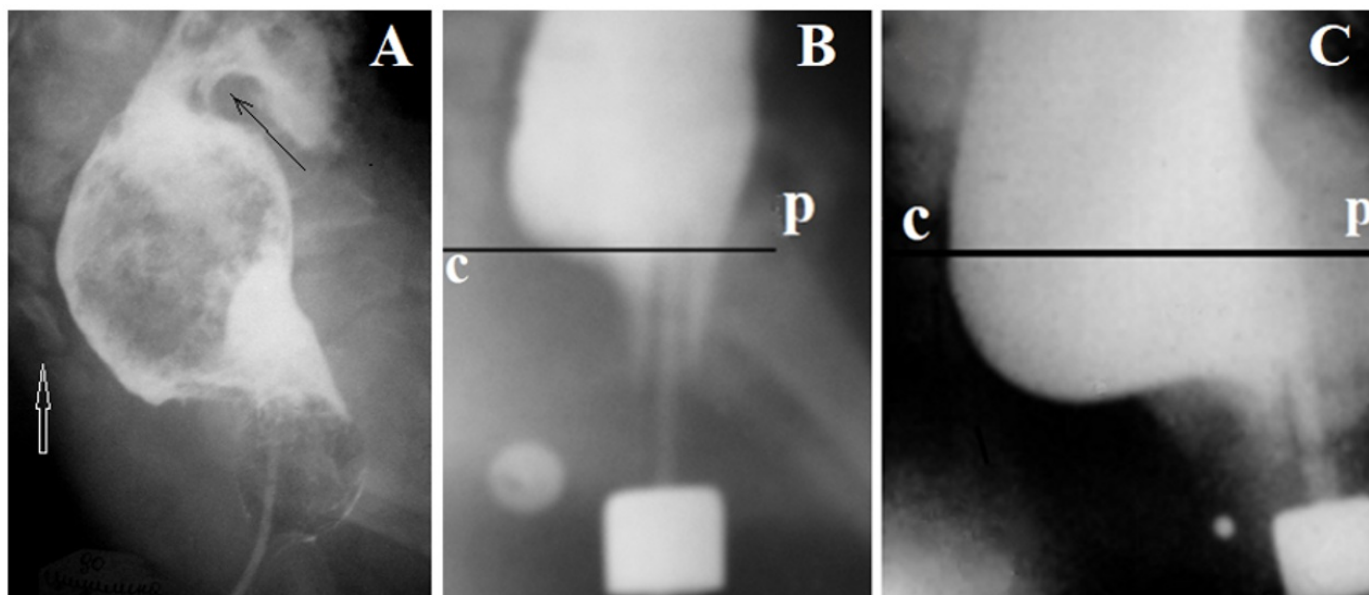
Lateral radiographs of the anorectum of patients with ARM with visible fistulas. (A). The Foley catheter was inserted into the rectum through the perineal fistula. A contrast agent was introduced into the rectum and the balloon was inflated to a diameter of 2 cm. The catheter was pulled into the anal canal until it stops. The balloon is stuck over a narrow fistula. The peristaltic wave (black arrow) pushes the fecal stone, which leads to stretching of the pelvic muscles below the last coccygeal vertebra (white arrow) and shortening of the anal canal. (B-C). Radiographs of the same girl with a vestibular fistula at different ages. P-C is the pubococcygeal line. The true diameter of the contrast marker strung on the tip of the enema is 1.6 cm. It is located near the fistula orifice. (B). At the age of 8 month the permanent contraction of the ectopic anal canal was observed during the barium enema. Its length is 2.5 cm, which corresponds to the age norm. The width of the rectum is 3.4 cm, which is greater than the maximum normal limit (3 cm) (megarectum). Barium penetrates the anal canal behind the tip of the enema. This shows the weakness of the PRM, which does not pull the posterior wall of the anal canal forward. (C). At the age of 1.5 years, she had severe constipation and soiling. The width of the rectum is 5.5 cm, which significantly exceeds the maximum limit of the norm for this age (3.7 cm). A megarectum is combined with a significant shortening of the anal canal. Its length is 1.9 cm (the minimal limit is 2.3 cm). Conclusion. An ARM with vestibular ectopy, megarectum, and descending perineum syndrome.
